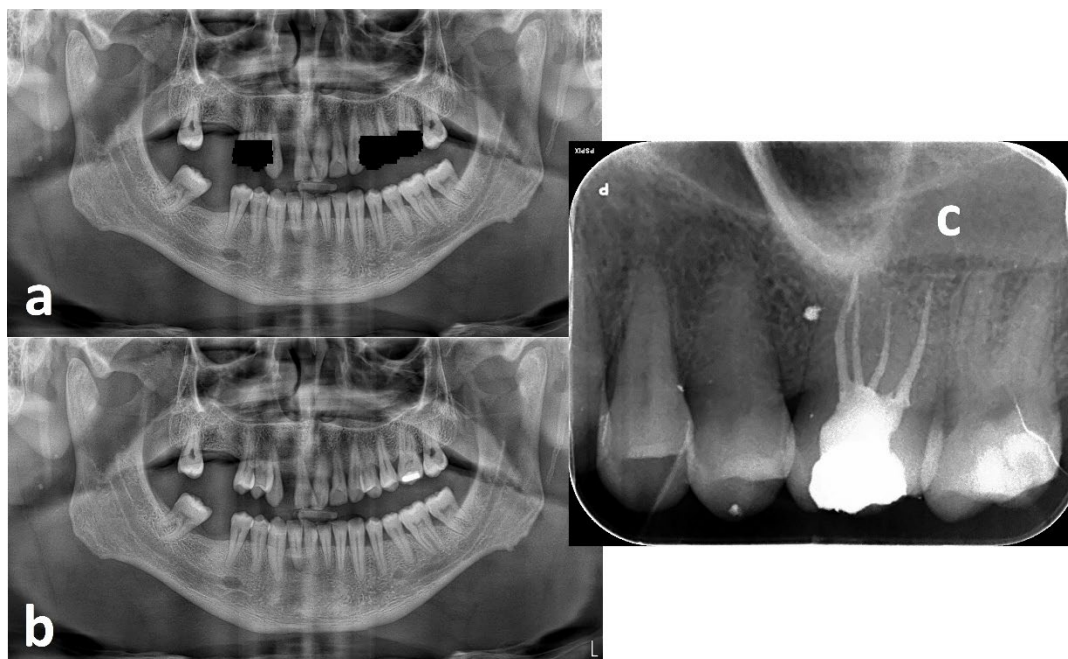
41-year-old male patient. Left maxillary first premolar scored 2 in one observation with PAN (a). For the same tooth, 0 was scored in all 4 observations with PAR. PAR was taken due to root canal treatment of the left maxillary first molar. Both left premolars were only visible on the final radiography (c). Observers included the unmasked version of this PAN in Level 2 in terms of image quality (b).
